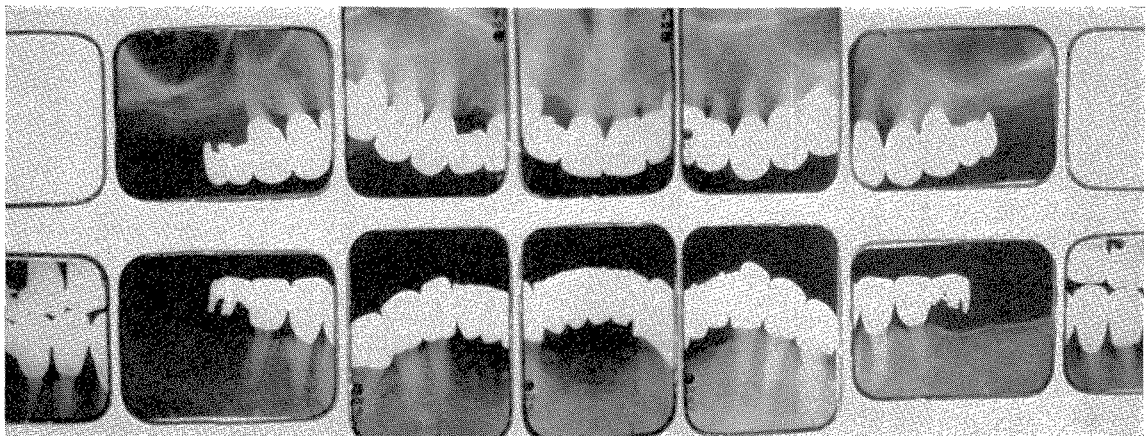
Roentgenograms taken in November, 1961, four years after completion.
